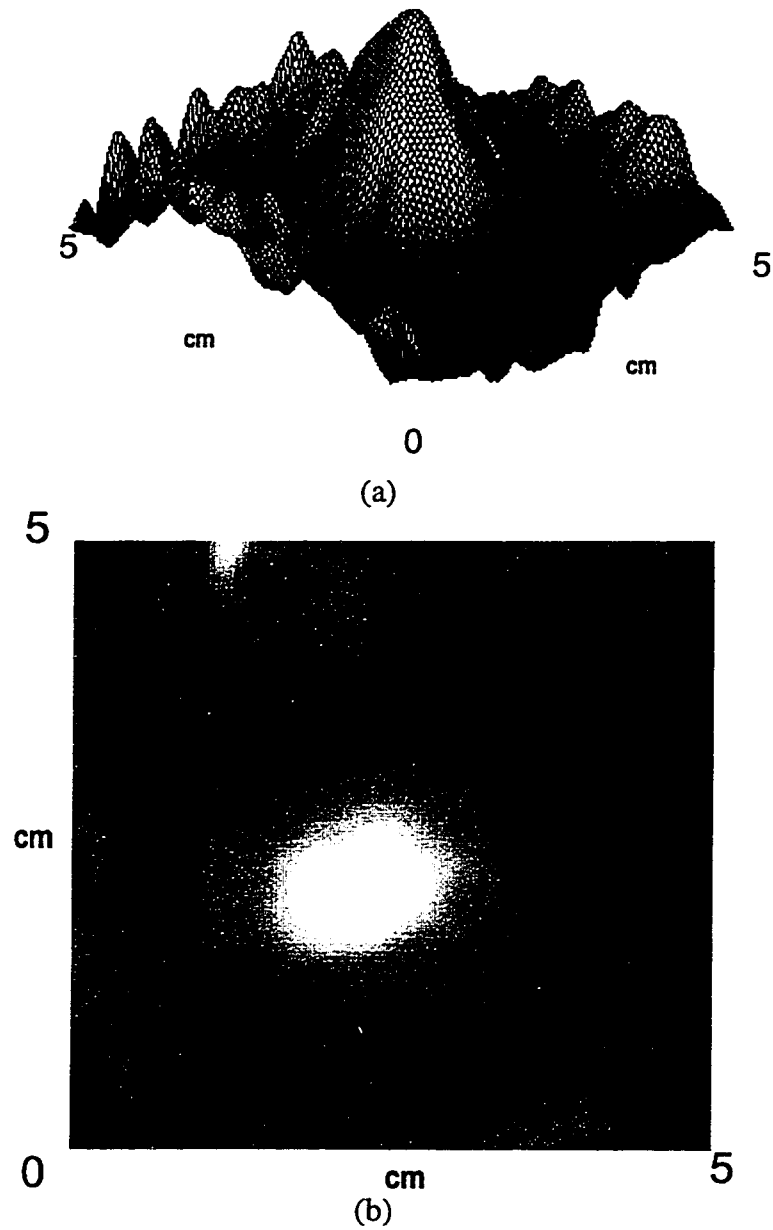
A three-dimensional topographic view of the tactile map made of an infiltrating ductal carcinoma in left breast of a 57 year old Caucasian woman. (b) False color contour plot showing the cancer in the center of the map. In CBE assessment, the mass is 1 cm by 1 cm while tactile imaging estimates it at 1.5 cm by 1.4 cm. Ultrasound puts its size at 0.8 cm by 0.8 cm. This patient was part of the later surgical trial, and upon excision the lump measured 1.1 cm by 0.9 cm.
